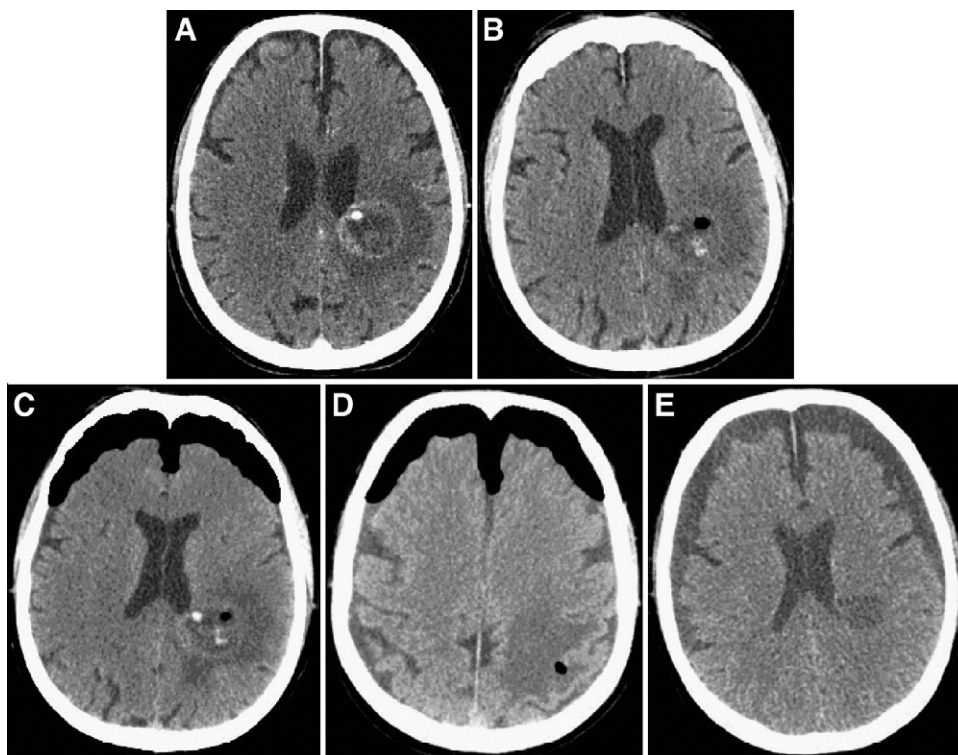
A: Preoperative CT showing a deep-seated left parietal lesion. B: Immediate postbiopsy CT showing an air bubble and a small hemorrhage within the lesion. C: CT performed 48 hours post biopsy showing pneumocephalus and (D) a new air bubble in the needle's tract. E: CT performed 6 days post biopsy showing filling of the subdural cavity with fluid and resolution of the pneumocephalus.
